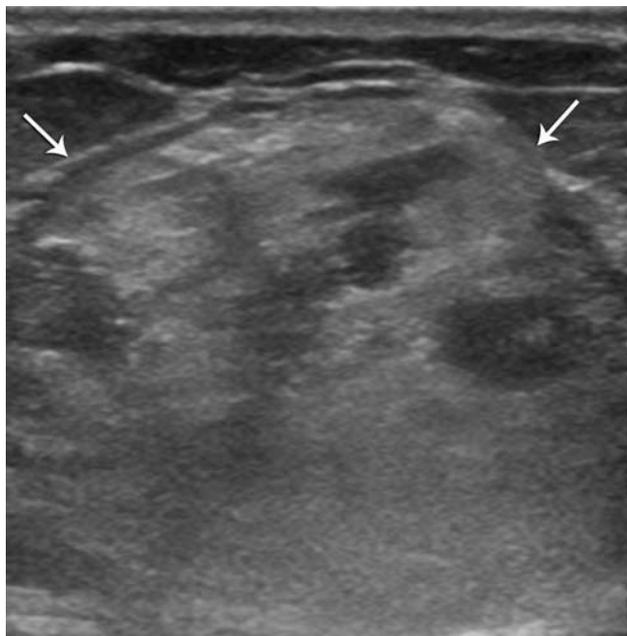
Ultrasound images showing an approximately 5-cm, oval circumscribed mass with internal heterogeneous echogenicity in the 12 o'clock direction of the right breast.
